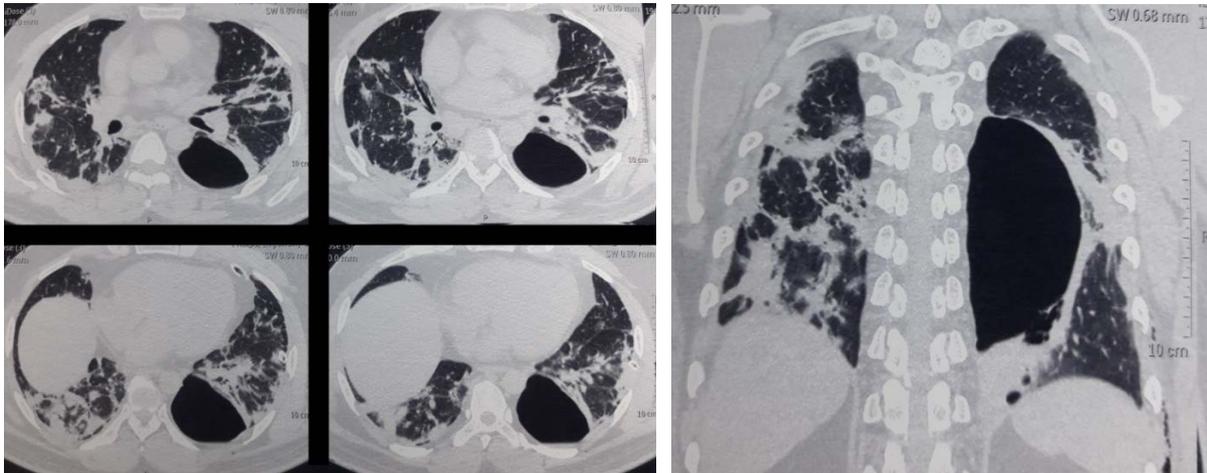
HRCT- architectural distortion of bilateral lung, multifocal-multilobar reticulations, linear fibrotic bands with traction bronchiectasis bilateral lower lobe, giant emphysematous bulla in left lower lobe
